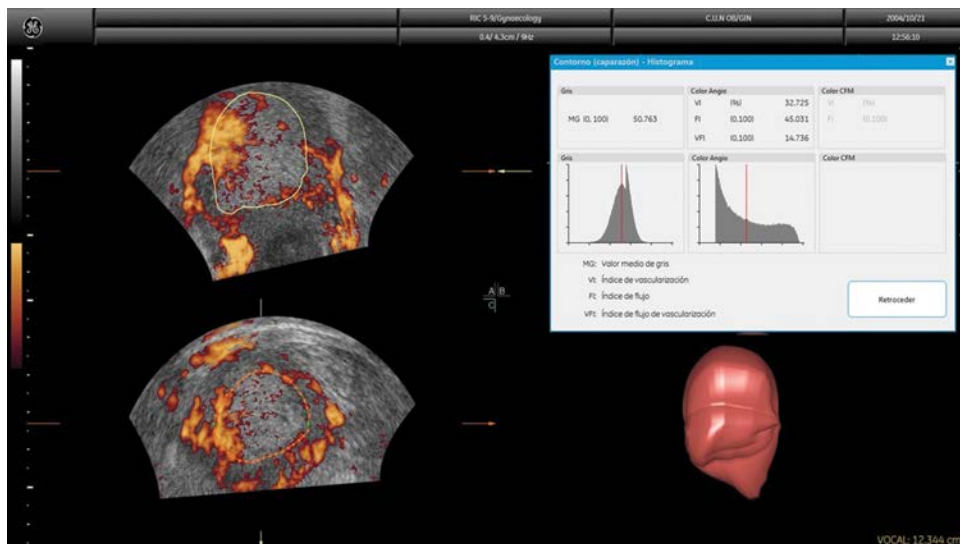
Endometrial volume and 3D vascular indices calculation using 3D ultrasound in a case of endometrial carcinoma.
